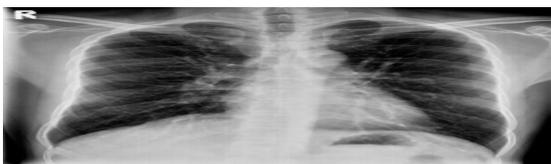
Chest x-ray-PA view- Tracheal narrowing at the level of sternal angle He underwent spirometry which showed severe obstructive ventilatory defect with no reversibility. The flow volume loop revealed flattening of both the inspiratory and expiratory loop suggestive of a fixed intra-thoracic obstruction.
